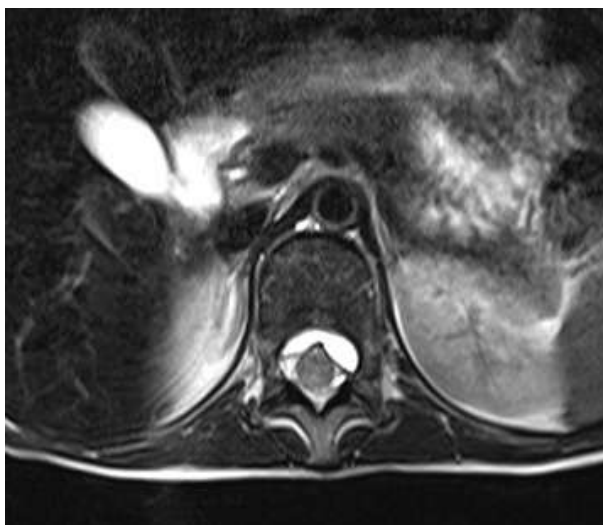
Pre-operative first MRI – Axial
